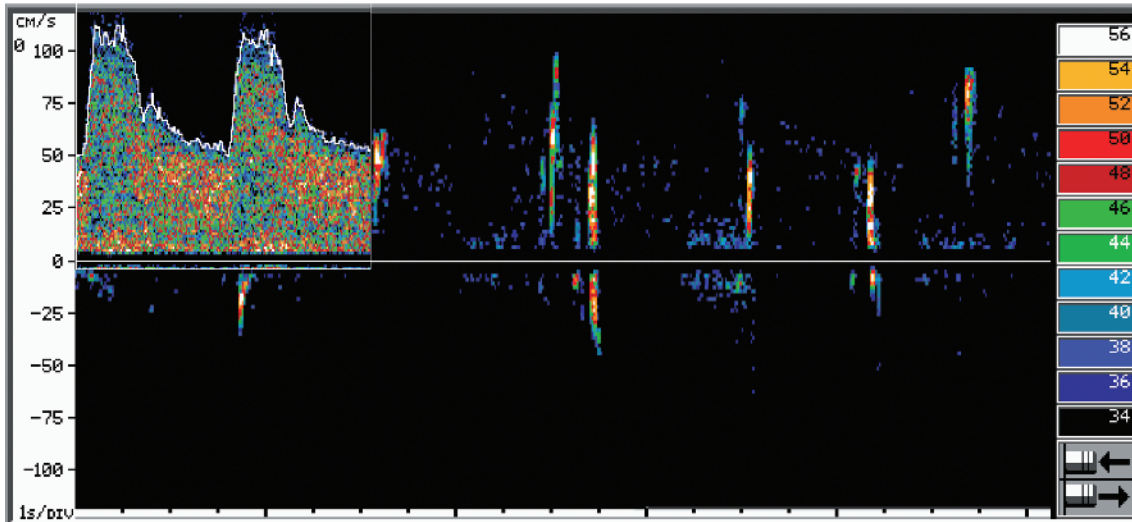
Spectral MCA waveform and embolic signals during TCD bubble test for right-to-left shunt. MCA waveforms (insert) are reflective of normal vessel patency. Air microbubble traces on spectral Doppler are seen as high-intensity transient signals (HITS). These HITS appeared after intravenous injection of agitated saline at rest. Gain was reduced to subtracted normal flow signals.
